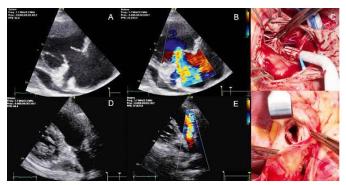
Findings in TTE of the TV (A,B,C) and PV (D,E,F); respectively 2D, colour doppler, intrapoperative.
